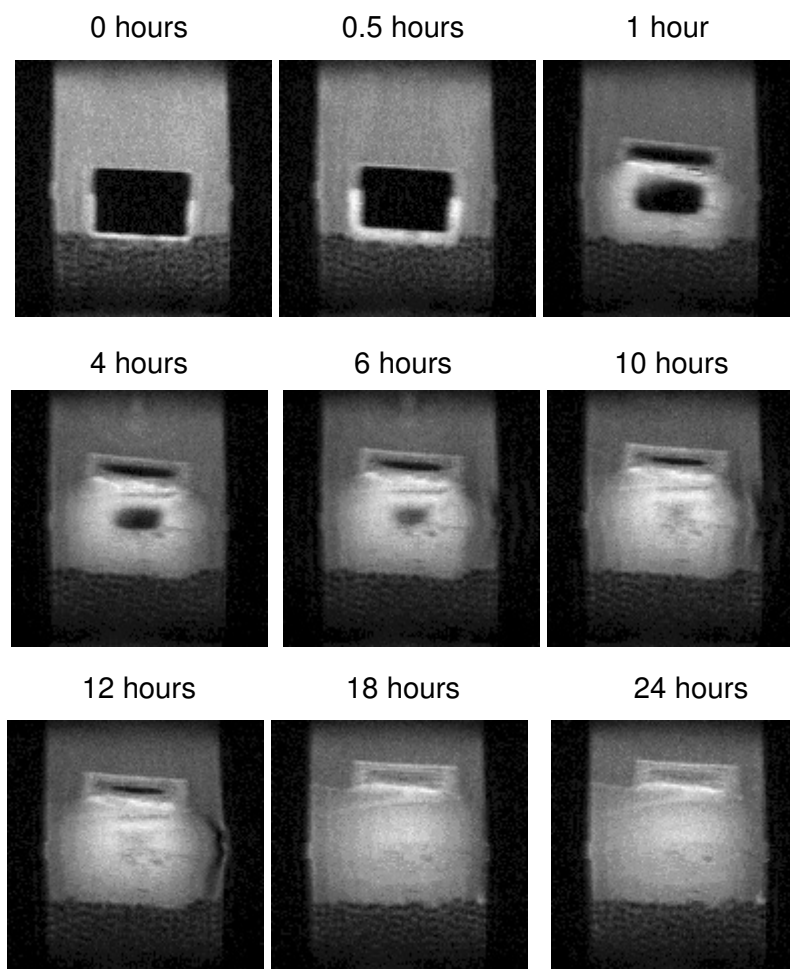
MRI images at specific time points displaying the swelling and erosion characteristics of the TLT during dissolution in PBS (pH 6.8, 37°C).
